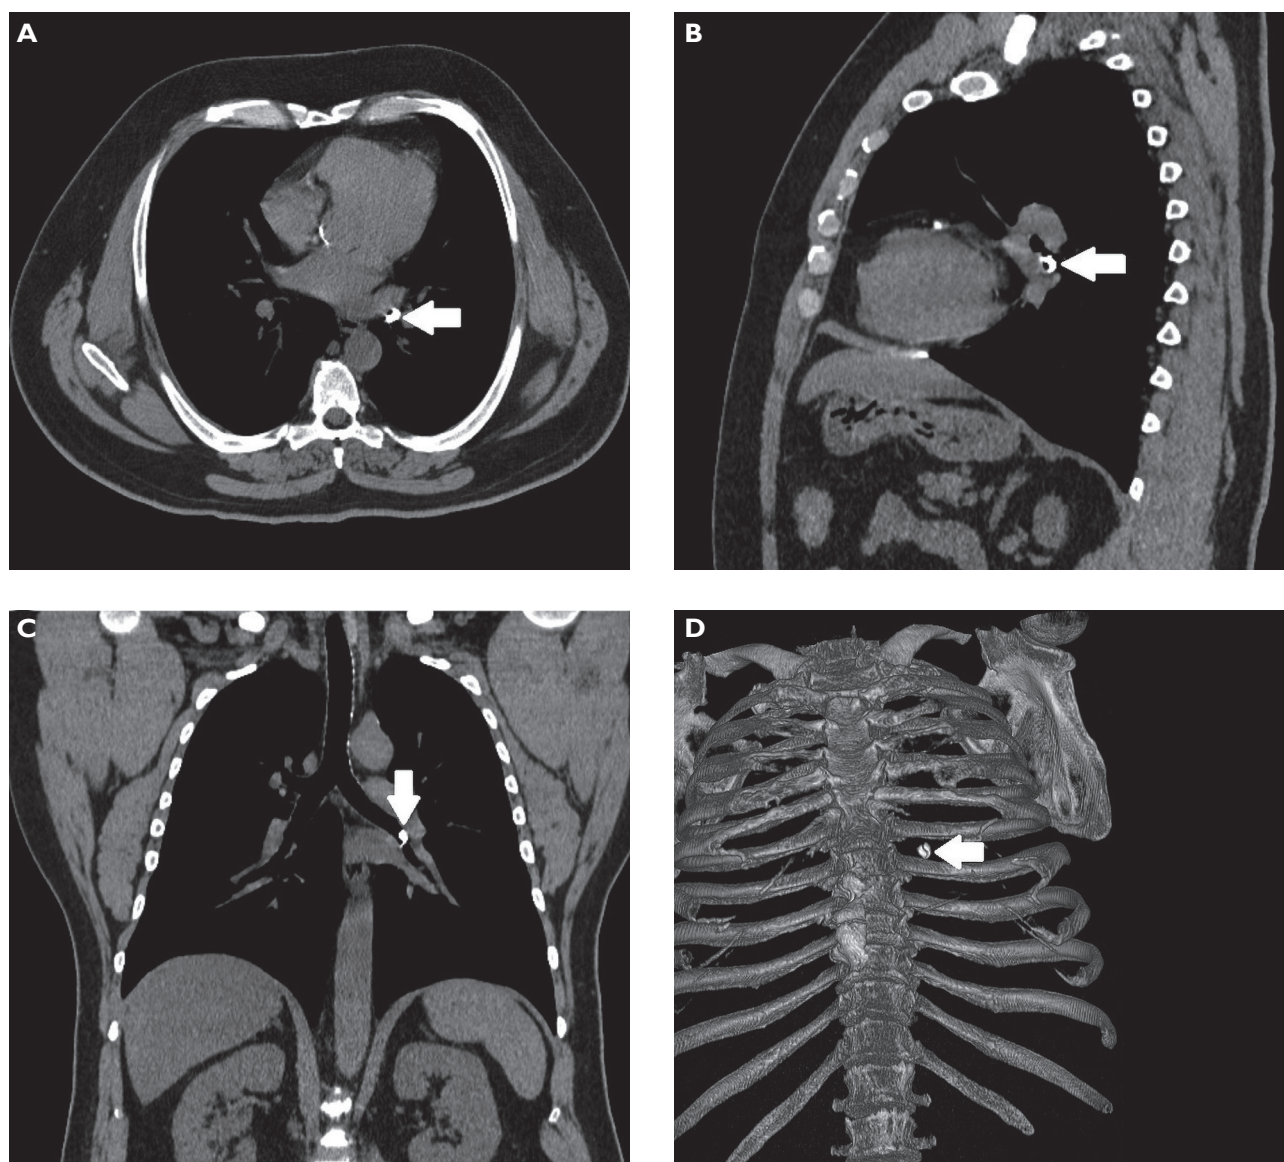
Computed tomography in the axial (A), sagittal (B) and coronal (C) sections, in addition to 3D reconstruction (D) demonstrating a dental crown in the left main bronchus (white arrows).
